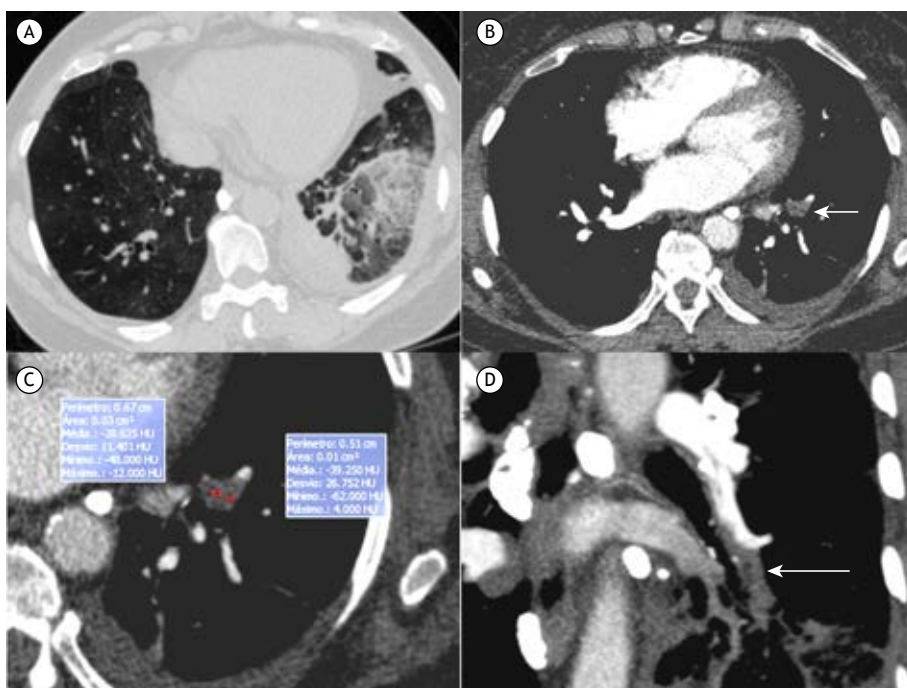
In A, unenhanced chest CT image (lung window) showing heterogeneous ground-glass opacities in the left lower lobe, with internal reticulation, compatible with pulmonary infarction. Note also the pleural reaction. In B, enhanced axial CT image showing a heterogeneous filling defect in the left lower-lobe artery (arrow). In C, magnified image of the emboli in B showing internal fatty density (–29 to –39 Hounsfield units). In D, coronal oblique reconstruction showing the heterogeneous emboli (arrow).
